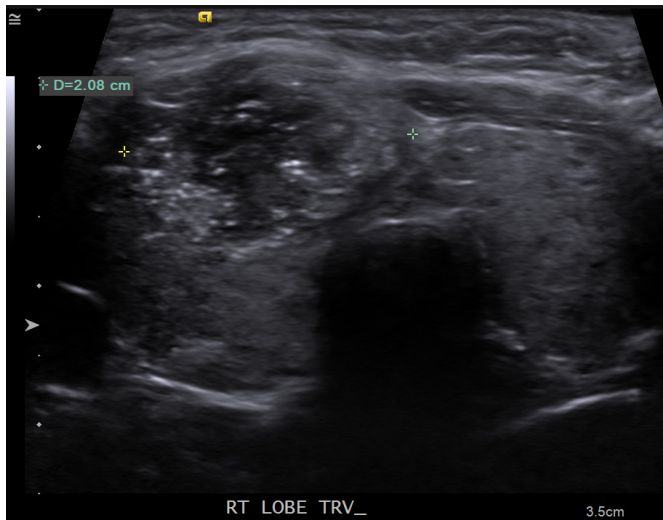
Ultrasound examination of the neck reveals a right thyroid nodule.
